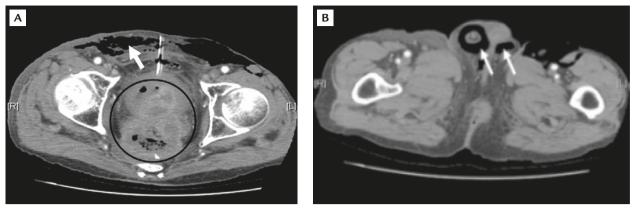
(A) Computed tomography of the retroperitoneum shows a soft tissue tumor with a lobulated margin and heterogeneous enhancement (black circle), subcutaneous emphysema (white arrow) and air within the colovesical fistula. (B) Computed tomography of the retroperitoneum shows air in the scrotum (white arrows).
